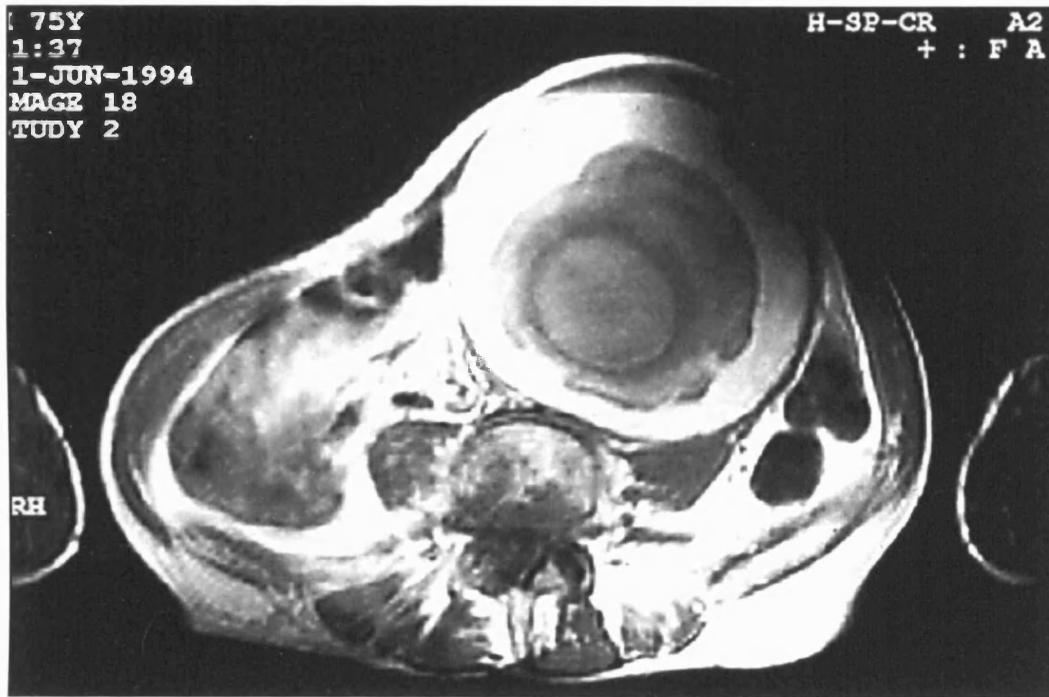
CT scan demonstrating an abdominal aortic aneurysm
